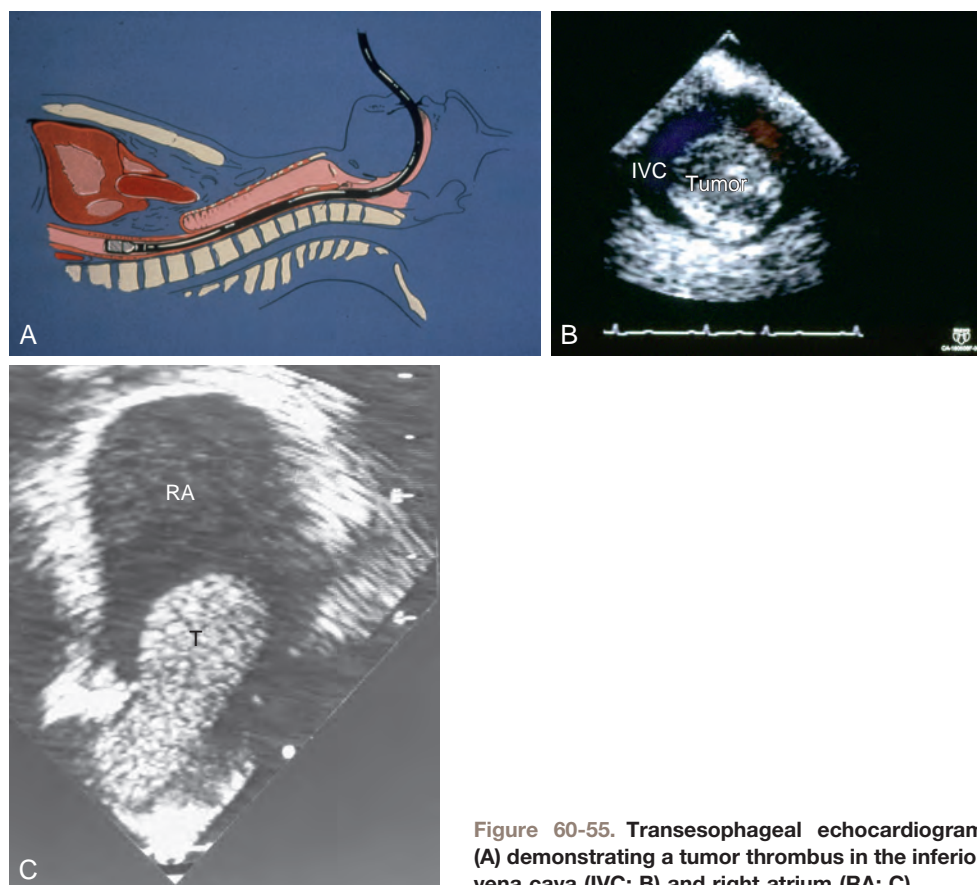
Transesophageal echocardiogram (A) demonstrating a tumor thrombus in the inferior vena cava (IVC; B) and right atrium (RA; C).
